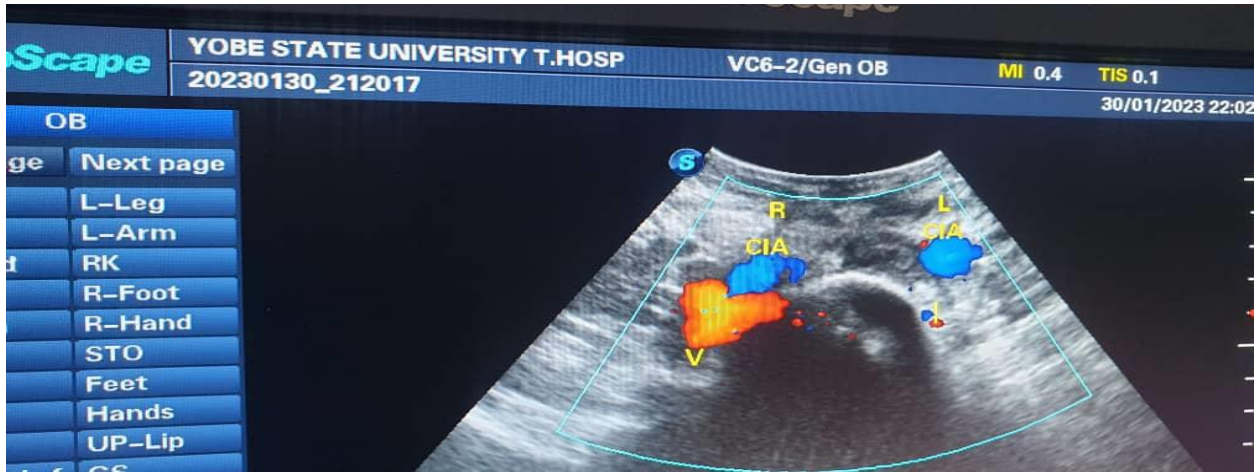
Transabdominal colour Doppler sonogram in transverse section showing filling defect in the left common iliac vein due to thrombus.
